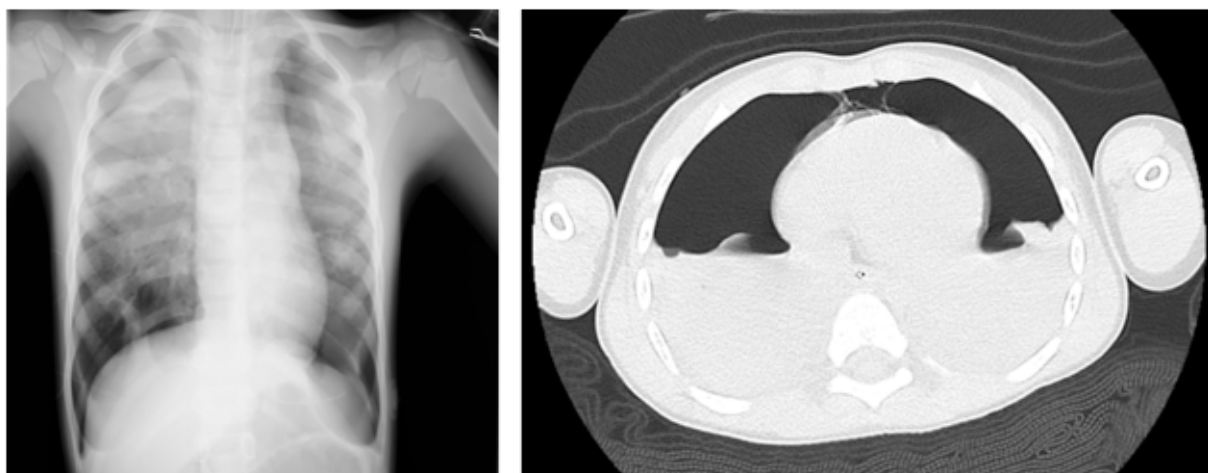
The chest X-ray and computed tomography on arrival showed pneumothorax and pleural effusion in both lungs.
